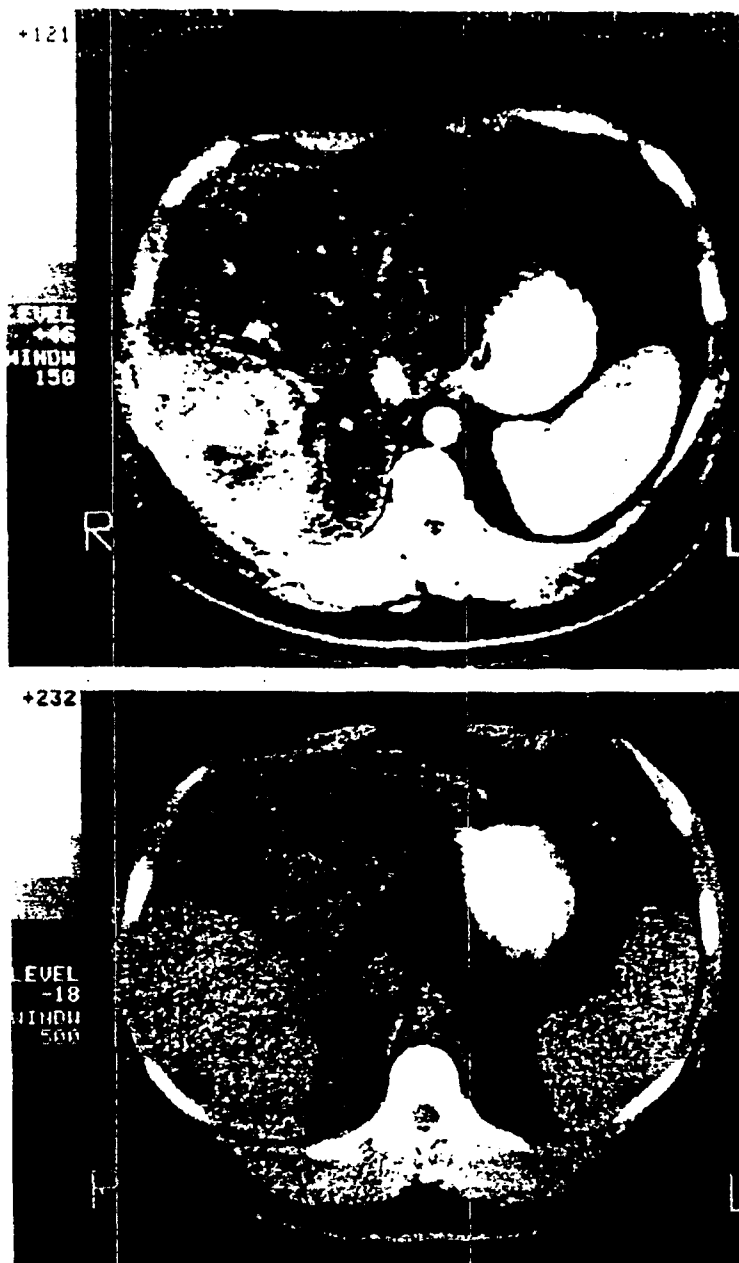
Top, computed tomographic scan of a hepatic angiosarcoma with contrast showing inhomogeneous contrast enhancement of mass lesion, which is indicative of its vascular nature. Bottom, computed tomographic scan without contrast showing a predominantly homogeneous 10-cm mass lesion in the right lobe of the liver that is of greater density than the remaining liver parenchyma.
